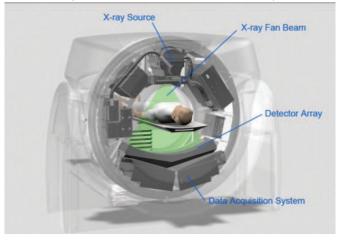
Computed Tomography Scanner. CT scans are often used in treatment planning for radiation therapy. During CT scanning, pictures of the inside of the body are created by a computer linked to an x-ray machine.
